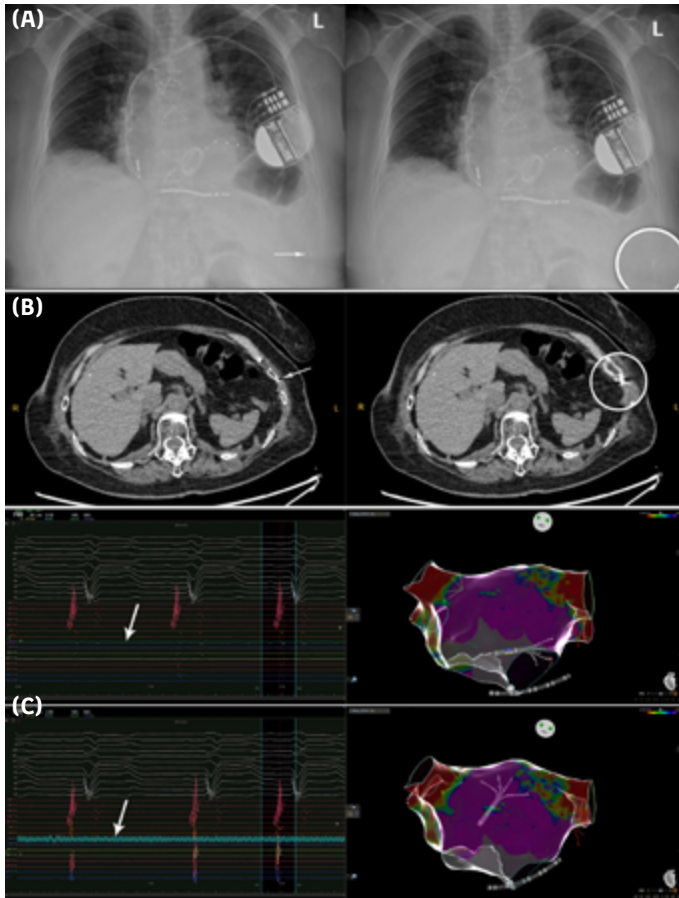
Teleradiograph showing the embolized segment (arrow) near the distal left rib cage in normal (left) and magnified (right) images (A). Computed tomography showing the embolized segment (arrow) in the distal portion of the intercostal artery in normal (left) and magnified (right) axial images. 3D mapping showing all five splines, with at least one located at the orifice of the mechanical valve and far-field atrial and ventricular signals on intracardiac electrograms (arrow) (upper). 3D mapping showing four splines in the left atrial cavity and continuous artifact recording in bipole 5-6 (arrow), with normal electrograms in the remaining electrodes (lower).
